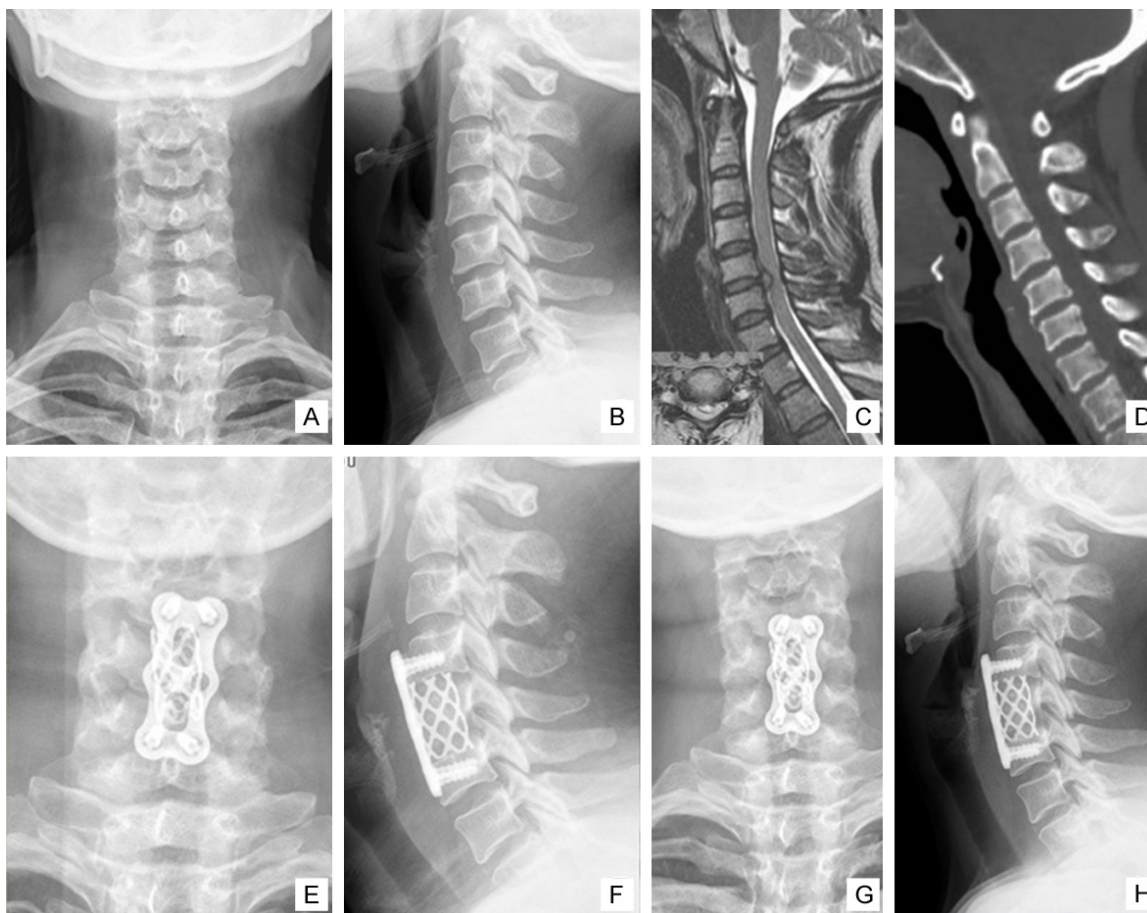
Typical imaging data. F, 40 y, both upper limbs pain and numbness for 1 year, aggravated for 2 months. A, B. Cervical X-ray indicates the degeneration of the cervical curvature and the formation of the anterior and posterior margin of the vertebrae. C, D. Preoperative MRI showed C5/6 disc herniation with spinal stenosis. E, F. Cervical X-ray after 3 months of ACCF. G, H. X-ray 1 year follow-up after operation, the internal fixation is in good position.
